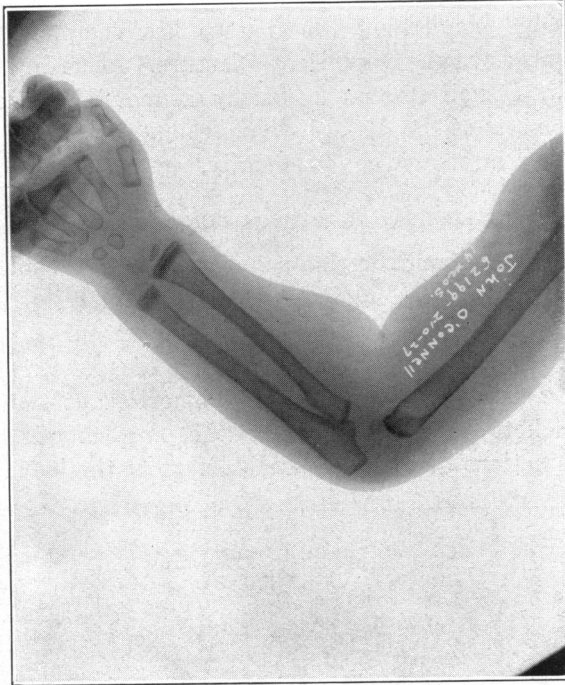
J. O., aged 14 months. X-ray photograph of arm after the administration of cod liver oil and phosphorus. As first pointed out by Phemister, inorganic phosphorus causes transverse bands to appear in the x-ray pictures of the bones. The phosphorus produces an intensely thick trabeculation which is responsible for the shadows. Only the parts of the bone in process of growth at the time of the phosphorus administration are affected. In this case the banding produced by the phosphorus gives a beautiful demonstration that the lower end of the ulna grows slightly faster than the lower end of the radius, that the lower end of the humerus and upper end of the radius grow much more slowly, and that the upper end of the ulna grows most slowly of all.
